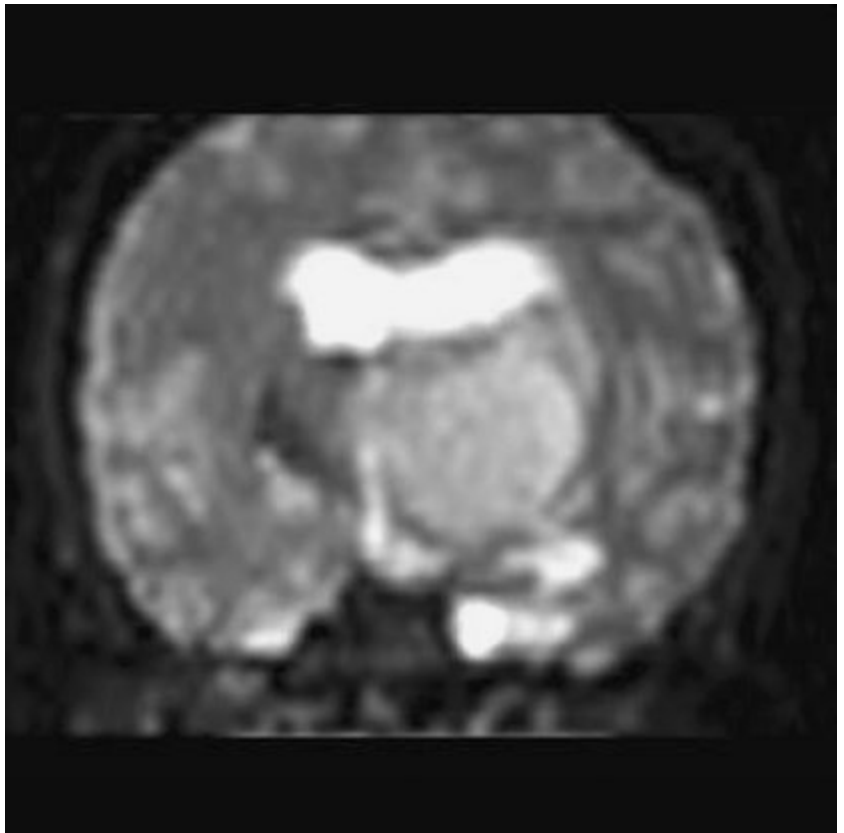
Coronal T2-weighted EPI demonstrates lesion.
